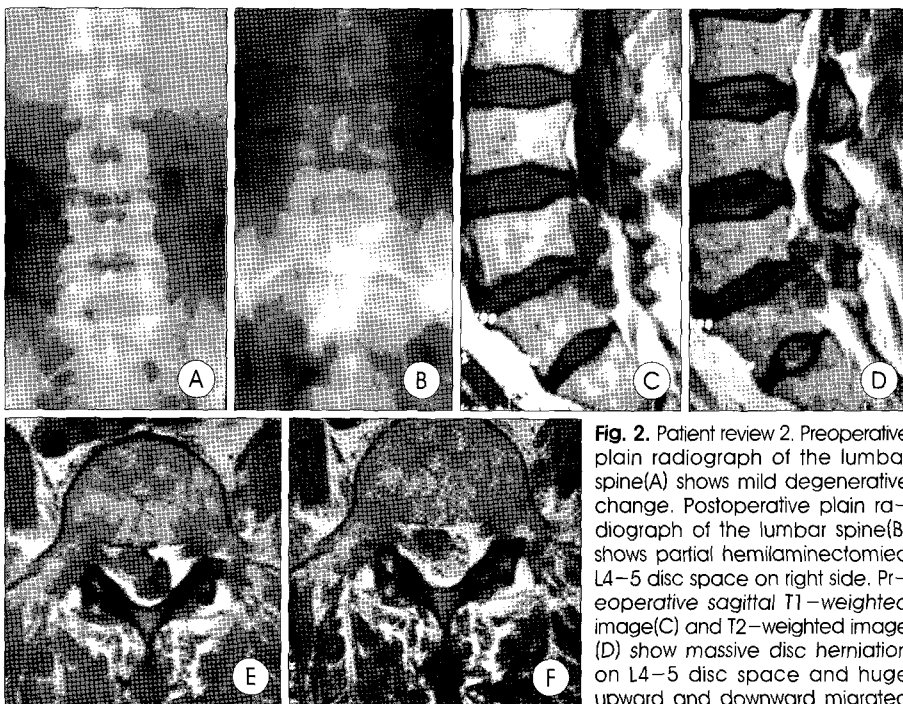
Patient review 2. Preoperative plain radiograph of the lumbar spine (A) shows mild degenerative change. Postoperative plain radiograph of the lumbar spine (B) shows partial hemilaminectomy on right side. Preoperative sagittal T1-weighted image (C) and T2-weighted image (D) show massive disc herniation on L4-5 disc space and huge upward and downward migrated
